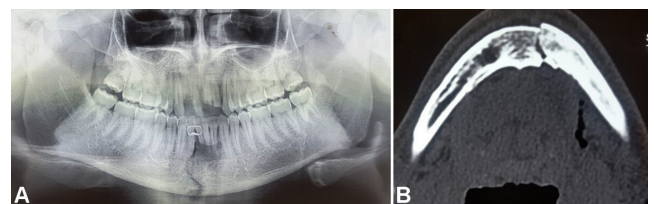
Preoperative radiographic evaluation of the anterior mandible fracture A. Displacement of <5 mm of the lower border on the mandible on the orthopantomograph (OPG); B. Displacement of <5 mm of the buccal cortex on the axial computed tomography (CT) scan.
